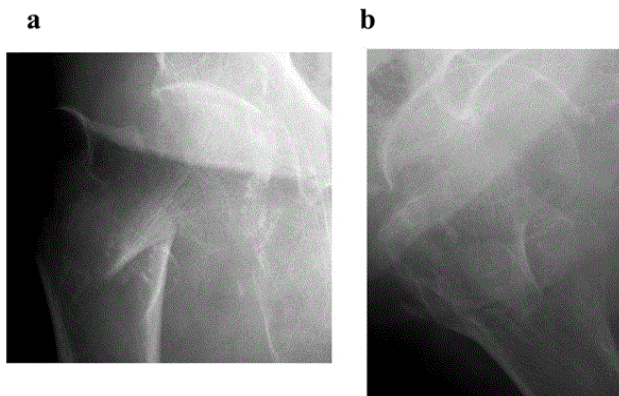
AP (a) and axial (b) radiographs of the right hip at the injury.
